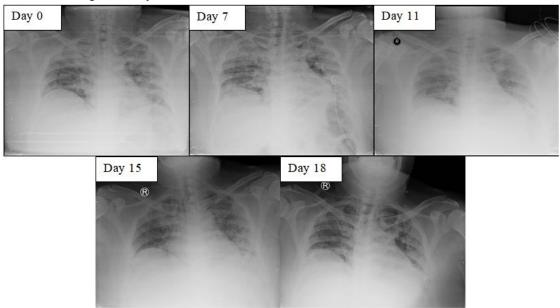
Serial chest X-ray.On going improvements on day 15 and 18 after three times of aaPRP treatment compared to day 0, 7 and 11.
